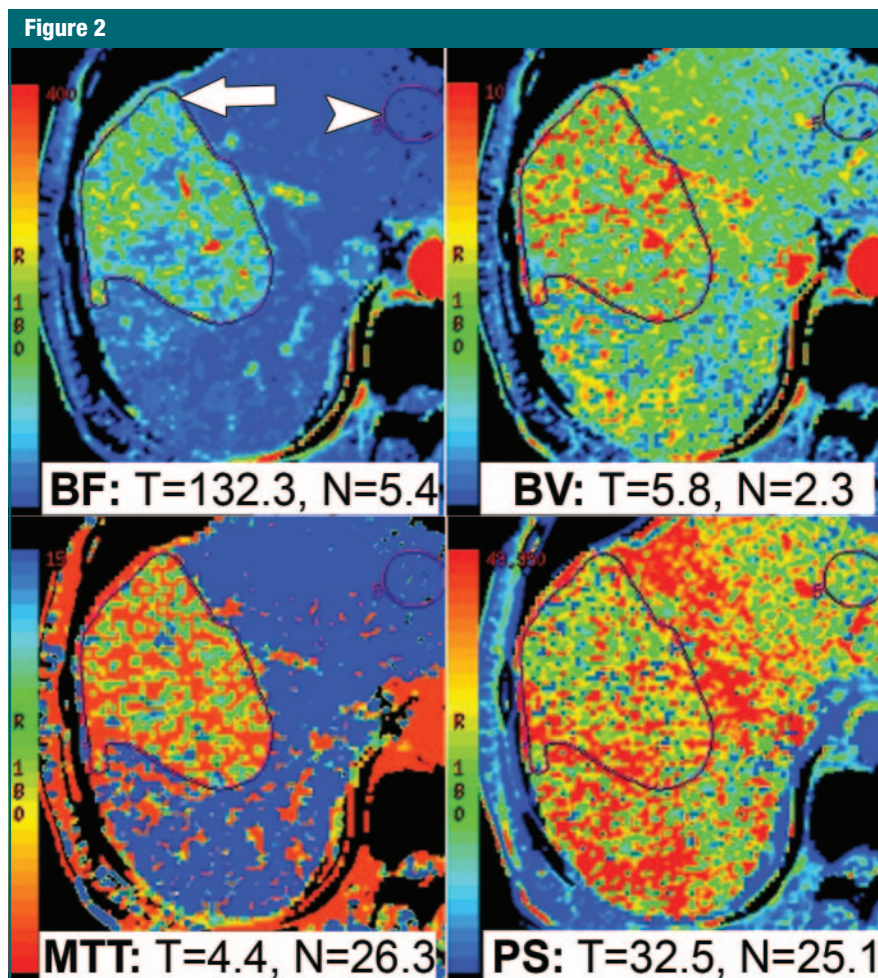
Transverse CT perfusion functional maps of BF, BV, PS, and MTT in 62-year-old man show large mass in right lobe of liver that has a distinct range of colors compared with background liver parenchyma. Perfusion values from ROI drawn for tumor (*T*) (arrow) and normal tissue (*N*) (arrowhead) show BF of 132.3 and 5.4 mL/100 g/min, BV of 5.8 and 2.3 mL/100 g, MTT of 4.4 and 26.3 seconds, and PS of 32.5 and 25.1 mL/100 g/min, respectively. Preferential arterial supply to HCC compared with dual vascular supply to liver results in higher BF, BV, and PS values and a lower MTT value in HCC, as shown in this example.
